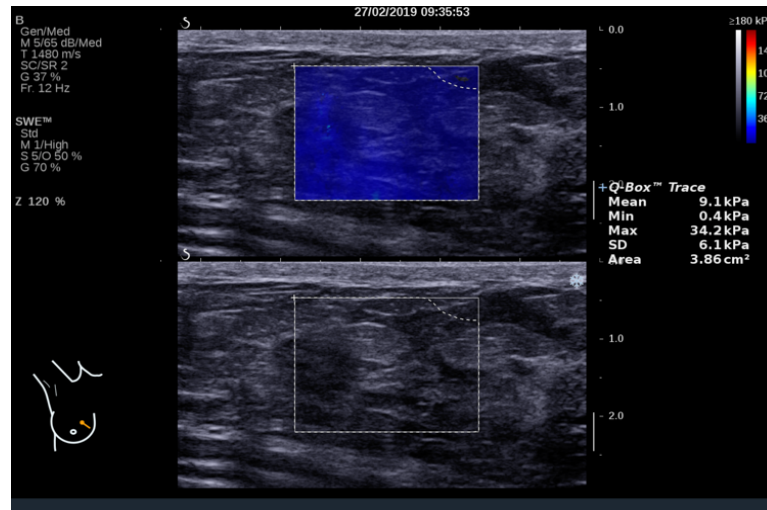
Shear wave ultrasound image with Free-Trace Q-Box™, avoiding a black hole
